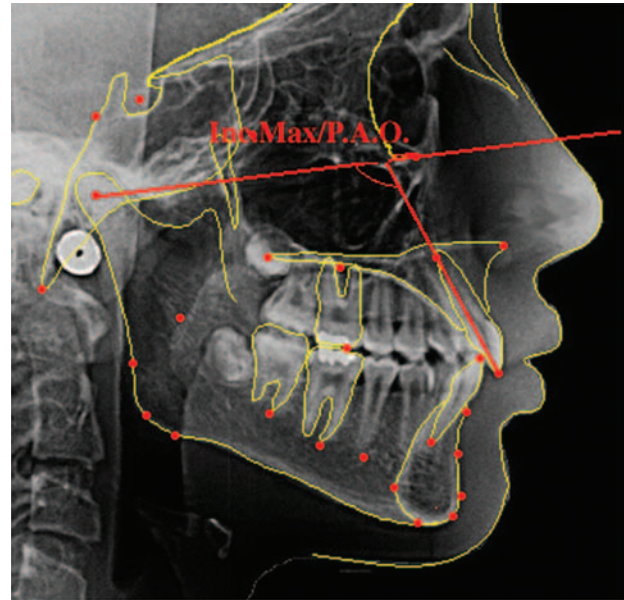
Teleprofile radiograph and cephalometric analysis
